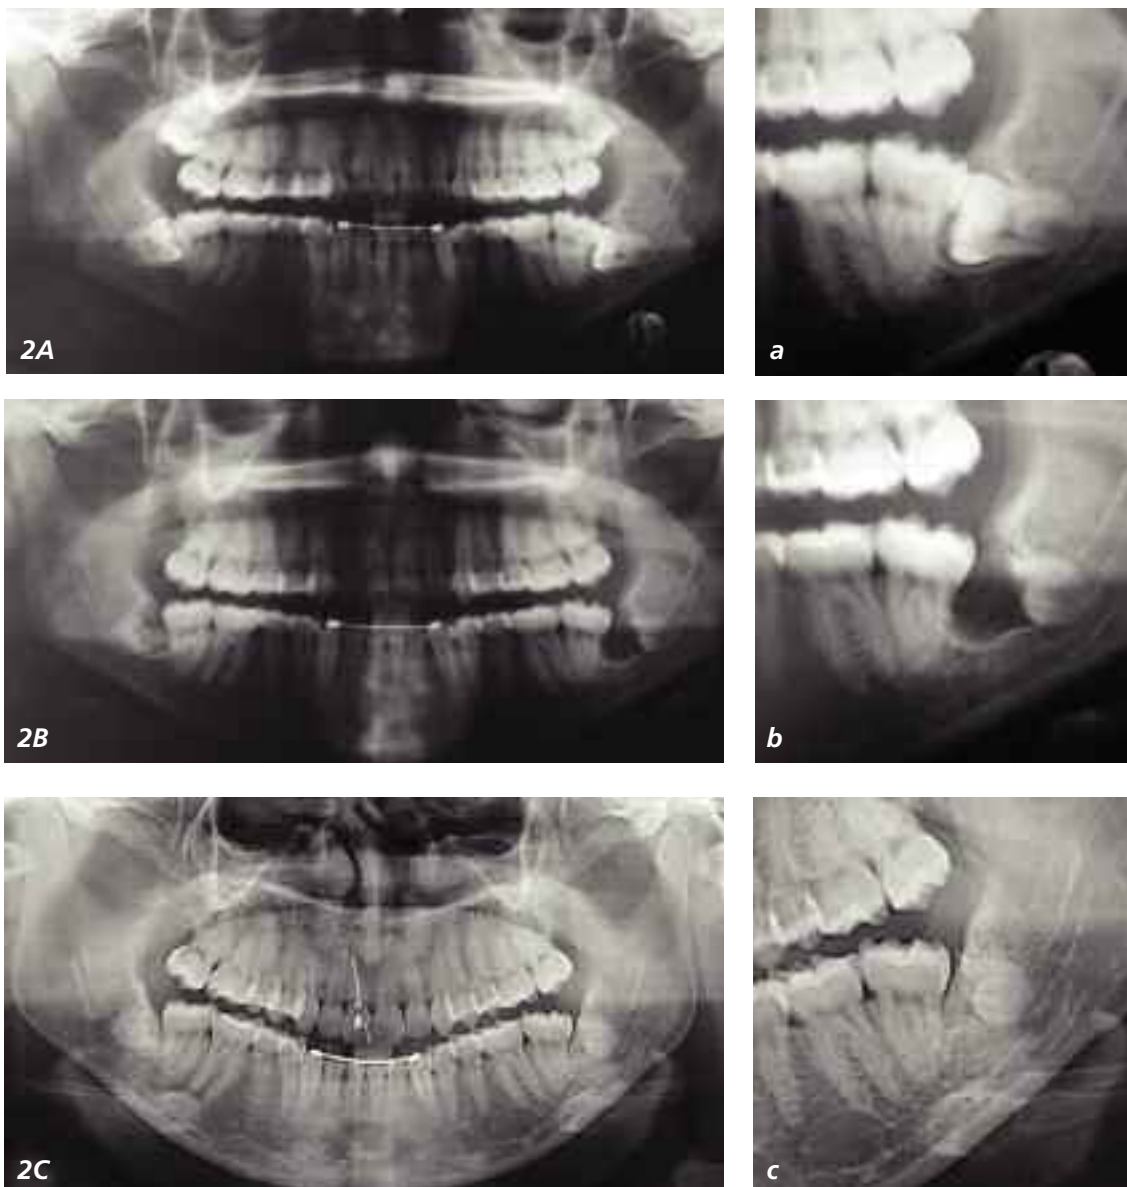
Panoramic radiograph of 22 year old female patient presenting with persistent pain associated with horizontally impacted teeth (A, a). Due to high risk of IAN injury (note darkening of canal as it crosses the roots) bilateral coronectomy was performed (B, b). 1 year follow-up (C, c) shows significant root fragment migration away from the IAN, ossification anterior to the roots and absence of periapical pathology
